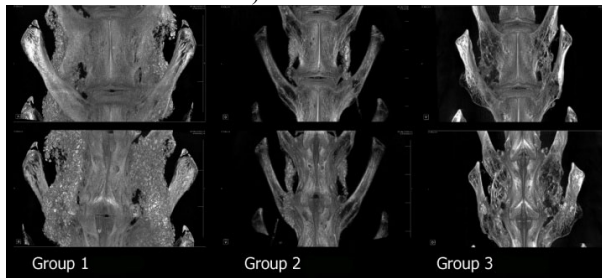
Micro CT models fusion sites at 26 weeks.
